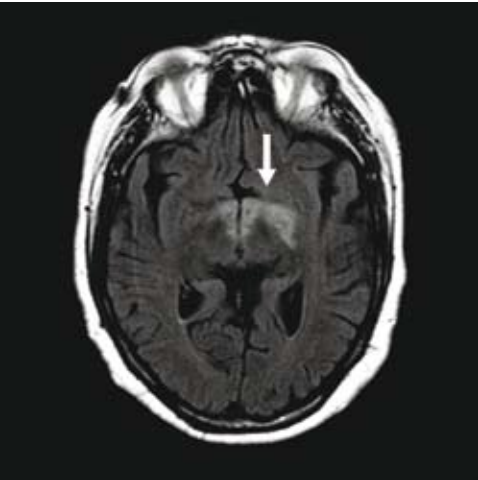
Brain MRI: axial flair.
